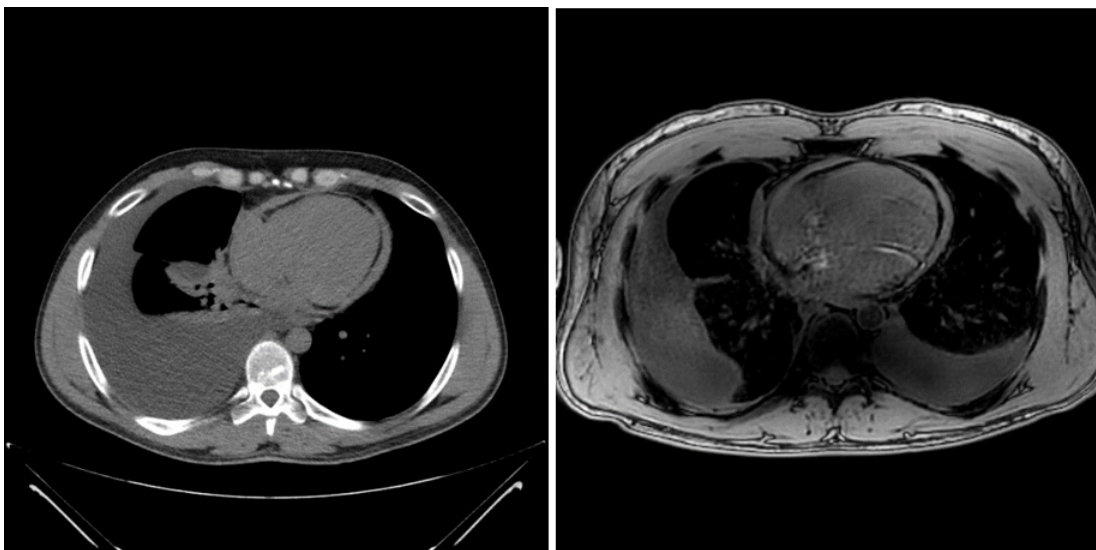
CT scan and MRI demonstrating pericardial thickening.
